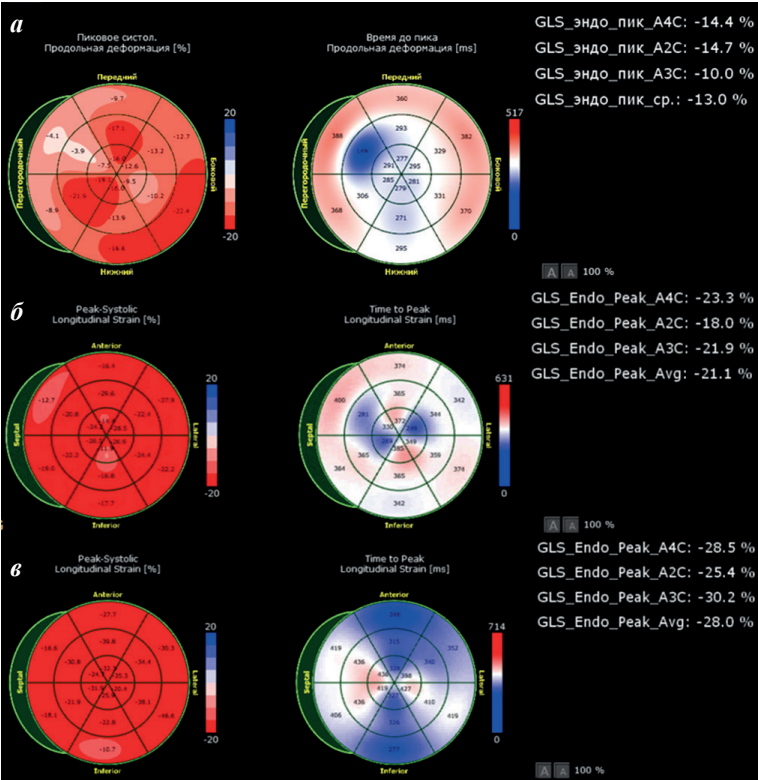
Assessment of left ventricular global longitudinal strain (LV GLS) by Speckle-tracking echocardiography: a, age 9 months at enrollment; b, 2 years after the ablation procedure; 2 years 9 months after the ablation procedure. A polar map with regional strain values and LV GLS values calculated from 18 segments is presented. Significant reduction in longitudinal deformity in basal, middle segments of the anteroposterior region at initial admission.
